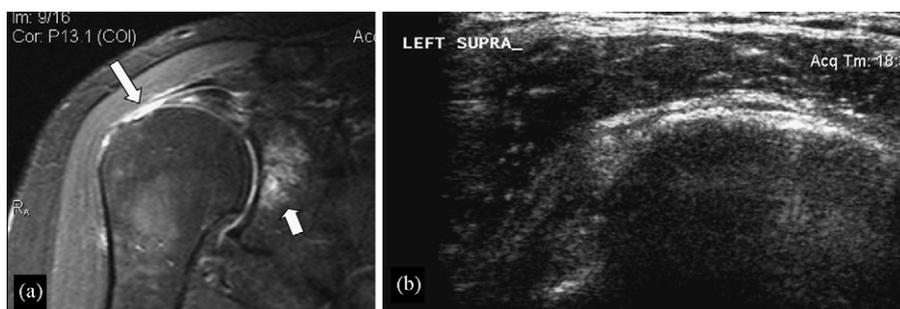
A 49-year-old woman with a recent fall and a surgically repaired massive full-thickness tear. (a) The coronal STIR MR image shows high signal intensity fluid replacing the insertion of the supraspinatus tendon at the greater tuberosity (arrow). There is also bone bruise in the subarticular bone marrow of the scapula (short arrow). (b) In the longitudinal sonogram, with the transducer placed anterior to the acromioclavicular joint and oriented 45°, the supraspinatus tendon is not visualized. Instead, the deltoid muscle is seen lying on the cortex of the humeral head.
